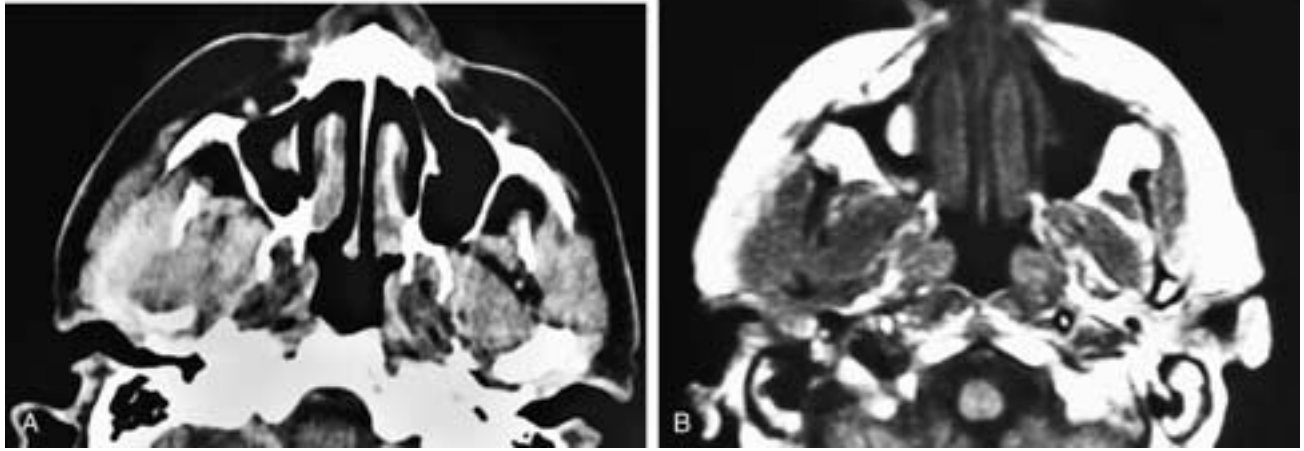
Axial contrast-enhanced CT scan (A) shows an infiltrating mass in the right infratemporal fossa, parotid gland, and parapharyngeal space. The mass has eroded the head of the mandible. In B, an axial proton density MR image, the mass has low to intermediate signal intensity. This patient had metastatic lung carcinoma.
